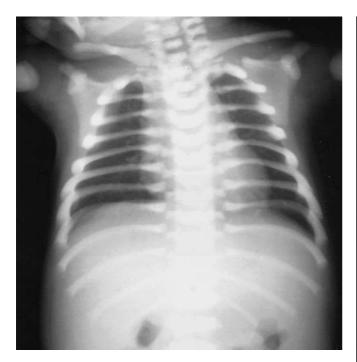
Roentgenogram demonstrating uniformly dense, homogeneous, and sclerotic bone with an absence of corticomedullary junctions
